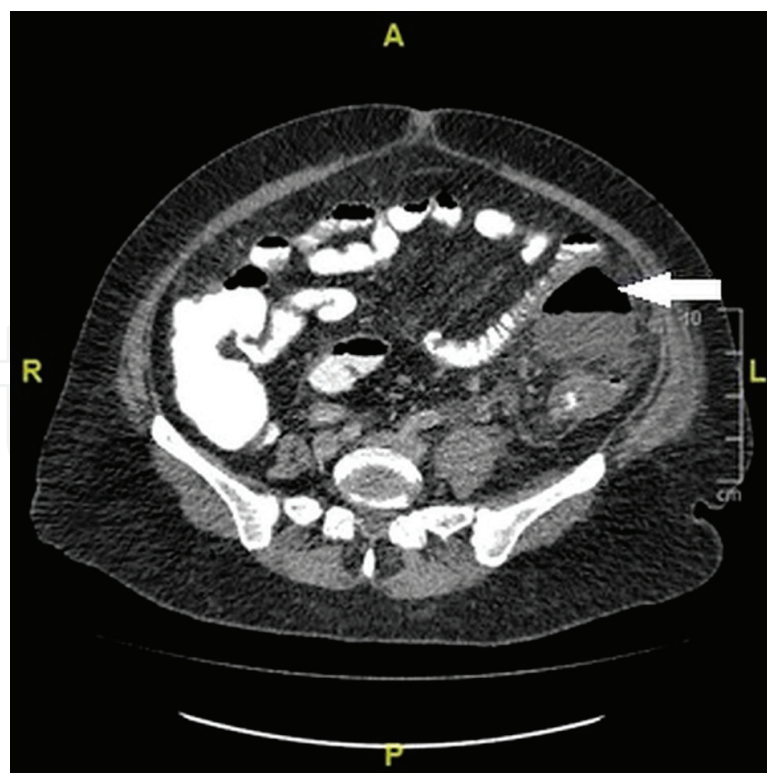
Computed tomography revealed a modified Hinchey stage II diverticulitis.
